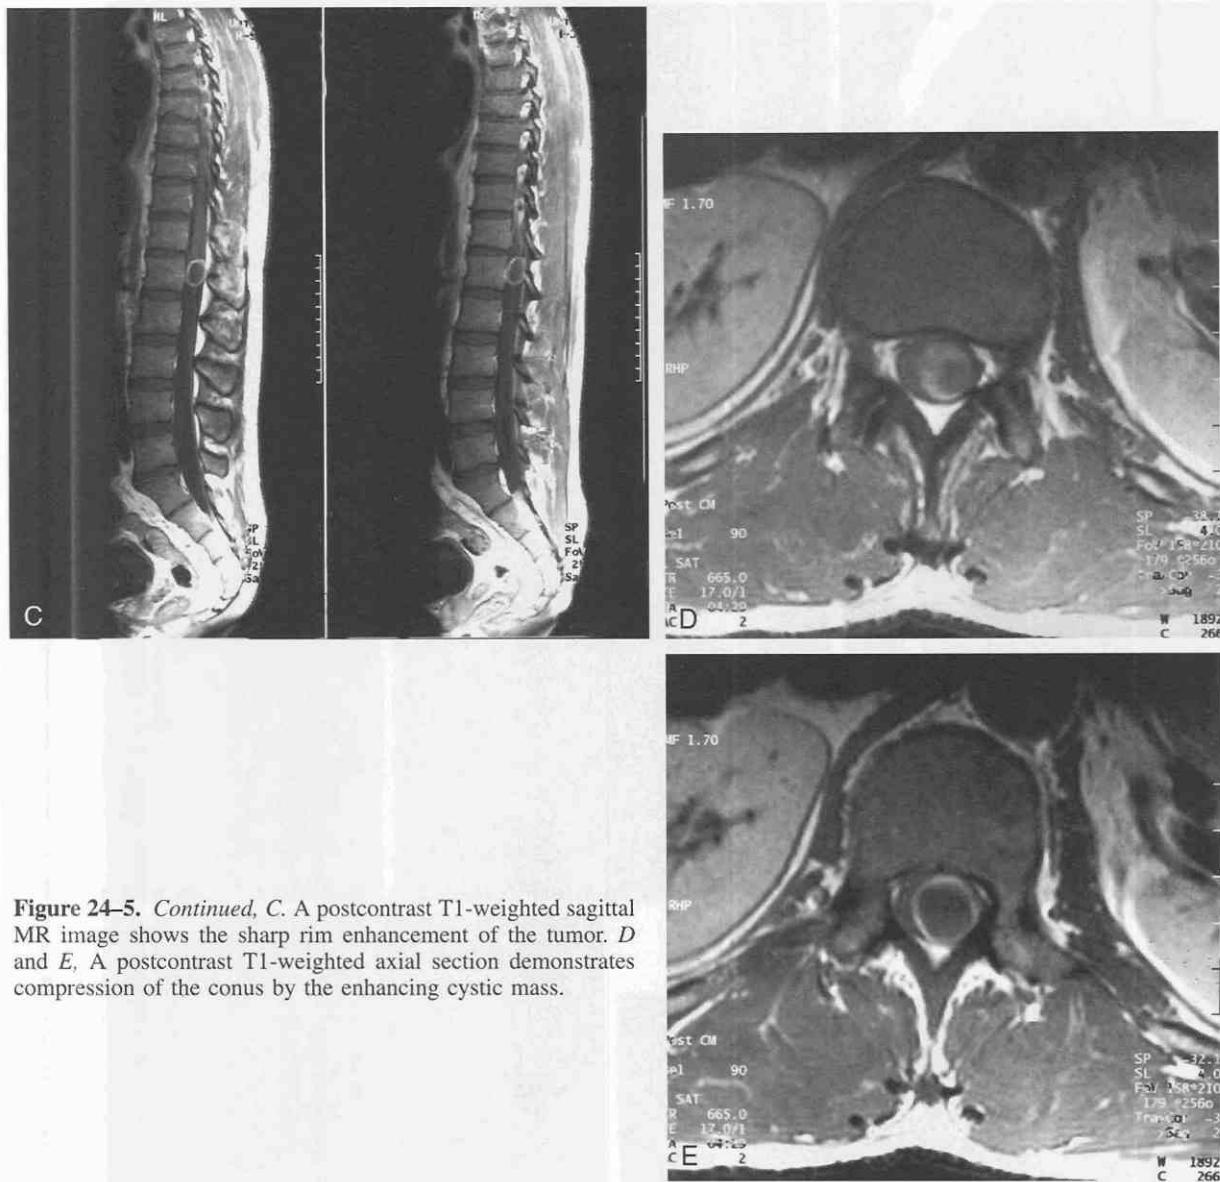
Continued, C.* A postcontrast T1-weighted sagittal MR image shows the sharp rim enhancement of the tumor. *D* and *E.* A postcontrast T1-weighted axial section demonstrates compression of the conus by the enhancing cystic mass.
